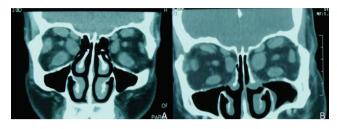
Coronal computed tomography of a patient with thyroid-associated ophthalmopathy (A). Coronal computed tomography images from the same patient after orbital decompression surgery (B). Postoperative images show the absence of the medial orbital wall and thinning of the cortical bone in the lateral wall
